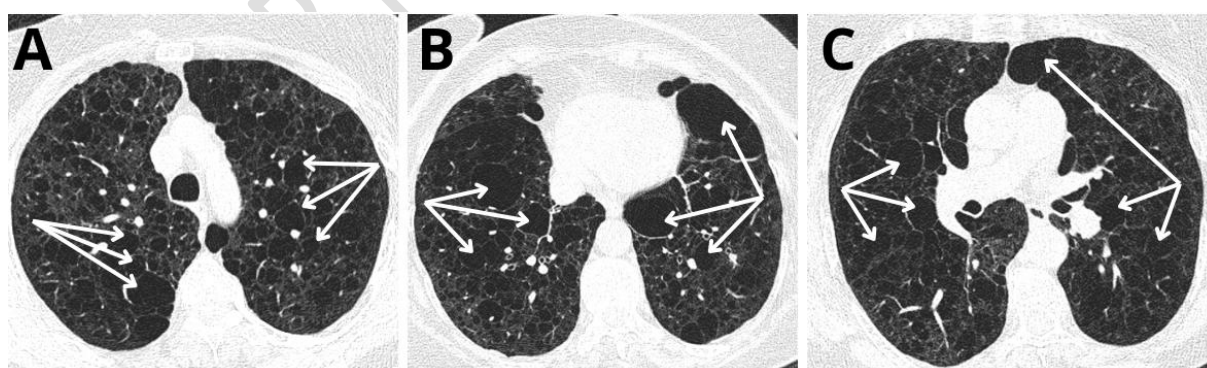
Thoracic CT axial parenchymal sections (A,B,C) showing thin-walled cystic images of diffuse distribution in both pulmonary hemifields of variable size and shape (white arrows).
